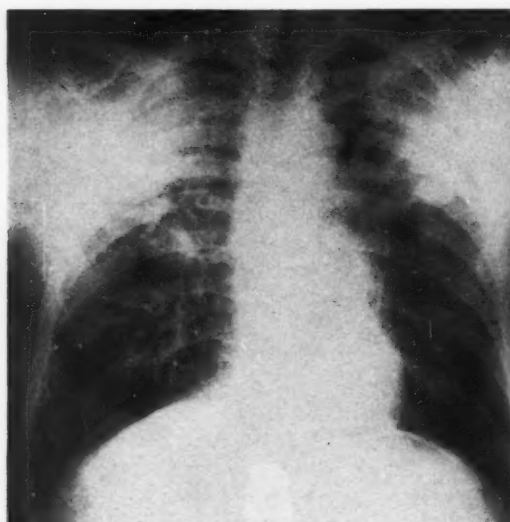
Case iv. Roentgenogram of chest; full inspiration.
